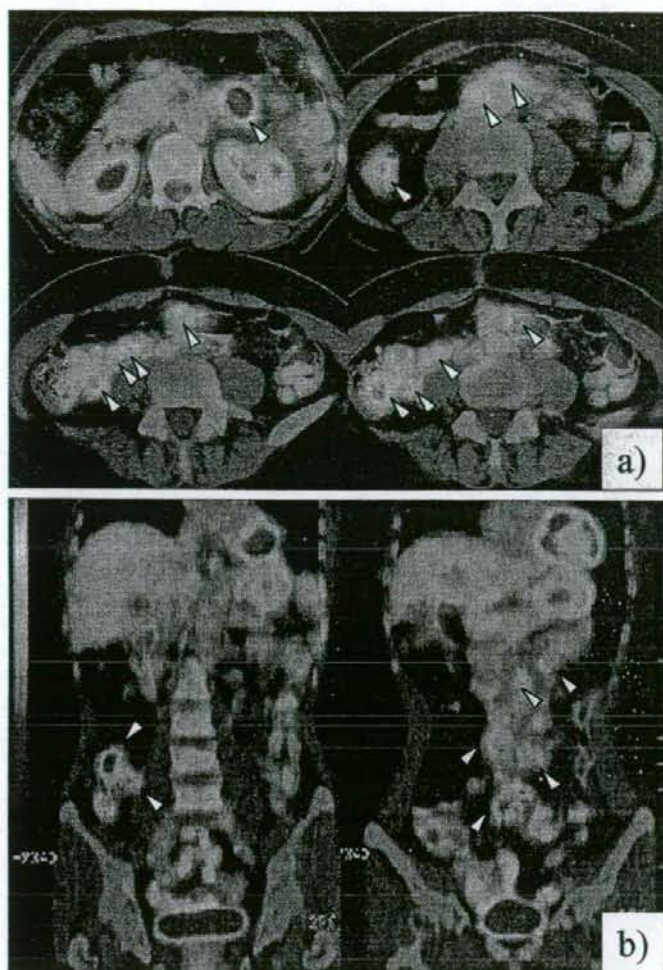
a) axial view, b) coronal view. PET/CT showed the hot spot (arrow) at the primary colon cancer, swollen regional and para-aortic lymph nodes and intra-abdominal nodules which suspected lymph nodes and peritoneal metastases.
